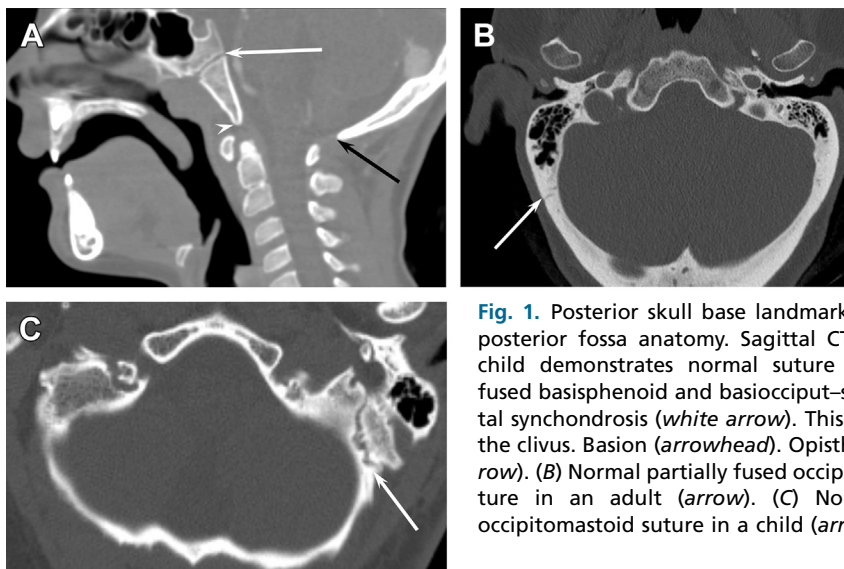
Posterior skull base landmarks. (A) Normal posterior fossa anatomy. Sagittal CT images in a child demonstrate normal suture between unfused basisphenoid and basiocciput-spheno-occipital synchondrosis (white arrow). This fuses to form the clivus. Basion (arrowhead). Opisthion (black arrow). (B) Normal partially fused occipitomastoid suture in an adult (arrow). (C) Normal unfused occipitomastoid suture in a child (arrow).
